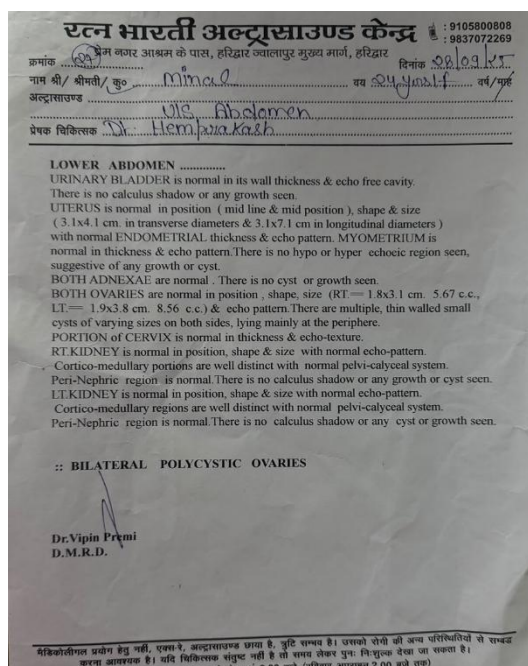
Ultrasonographic findings before treatment showing bilateral polycystic ovarian morphology. Ultrasonography revealed a normal-sized uterus and multiple small peripheral cysts in both ovaries, consistent with bilateral polycystic ovaries.
